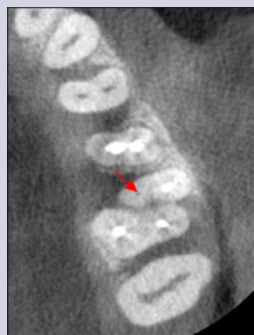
Axial CBCT slice of maxillary left quadrant. Note missed MB2 canal of tooth #14.
